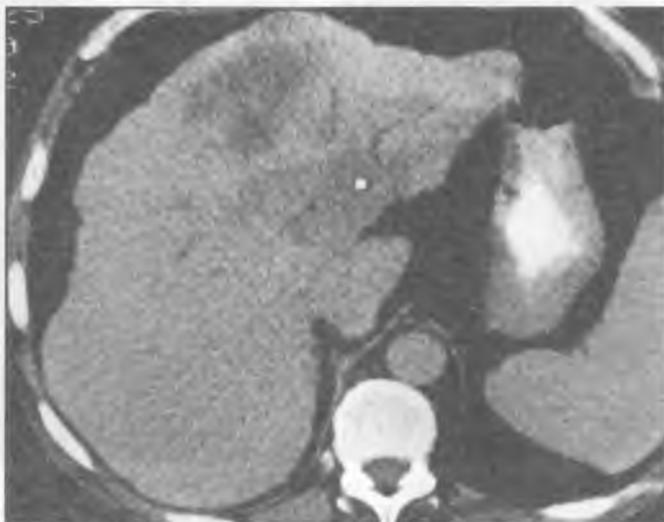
Dynamic CT shows a large low attenuation hepatoma in liver cirrhosis
